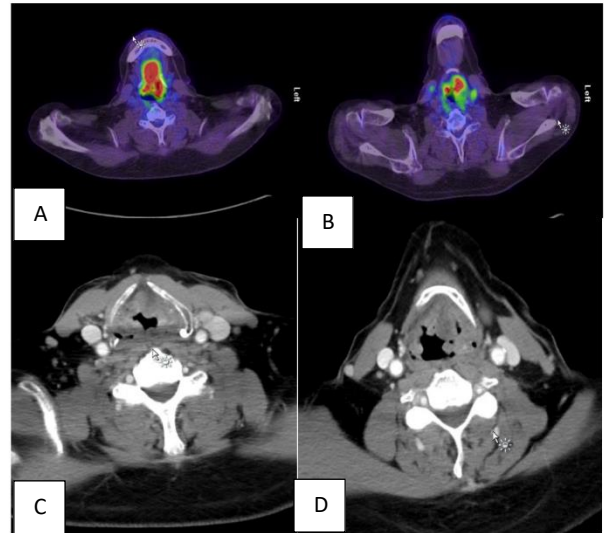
PET scan and CT-scan of the supraglottic and glottic lesion
